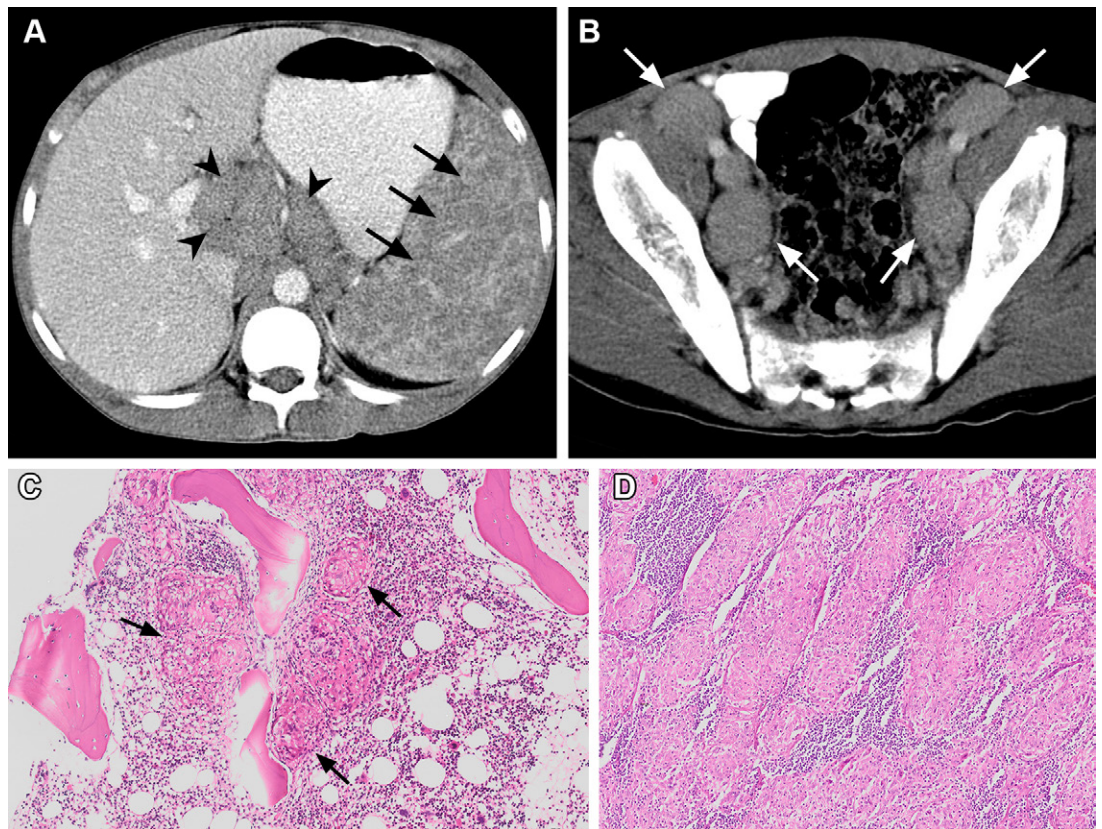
Abdominal sarcoidosis in a 16-year-old adolescent boy with fever and weight loss. Hepatosplenomegaly and cervical and inguinal lymphadenopathies were detected at physical examination. (A) Axial contrast-enhanced CT image shows splenomegaly and numerous small poorly defined hypoattenuating splenic lesions (arrows) and upper abdominal lymphadenopathies (arrowheads). (B) Axial CT image of the pelvis shows bilateral parailiac lymphadenopathies (arrows).
